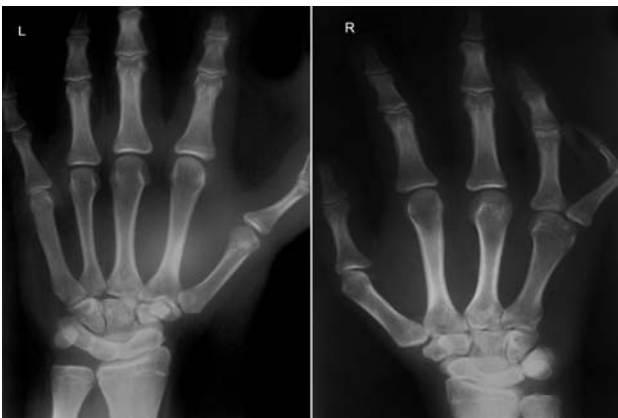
Posteroanterior radiograph of the hands, showing the SLTC on the left and SLC with absent fifth ray on the right.
